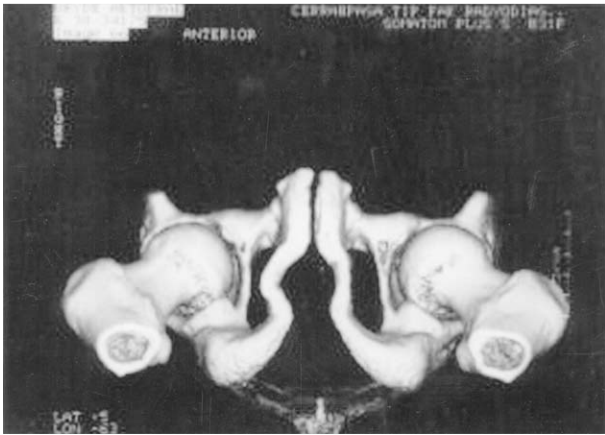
Preoperative 3-D CT images of pelvic outlet is seen as highly restricted with decreased bone density and pseudofracture apparant.
